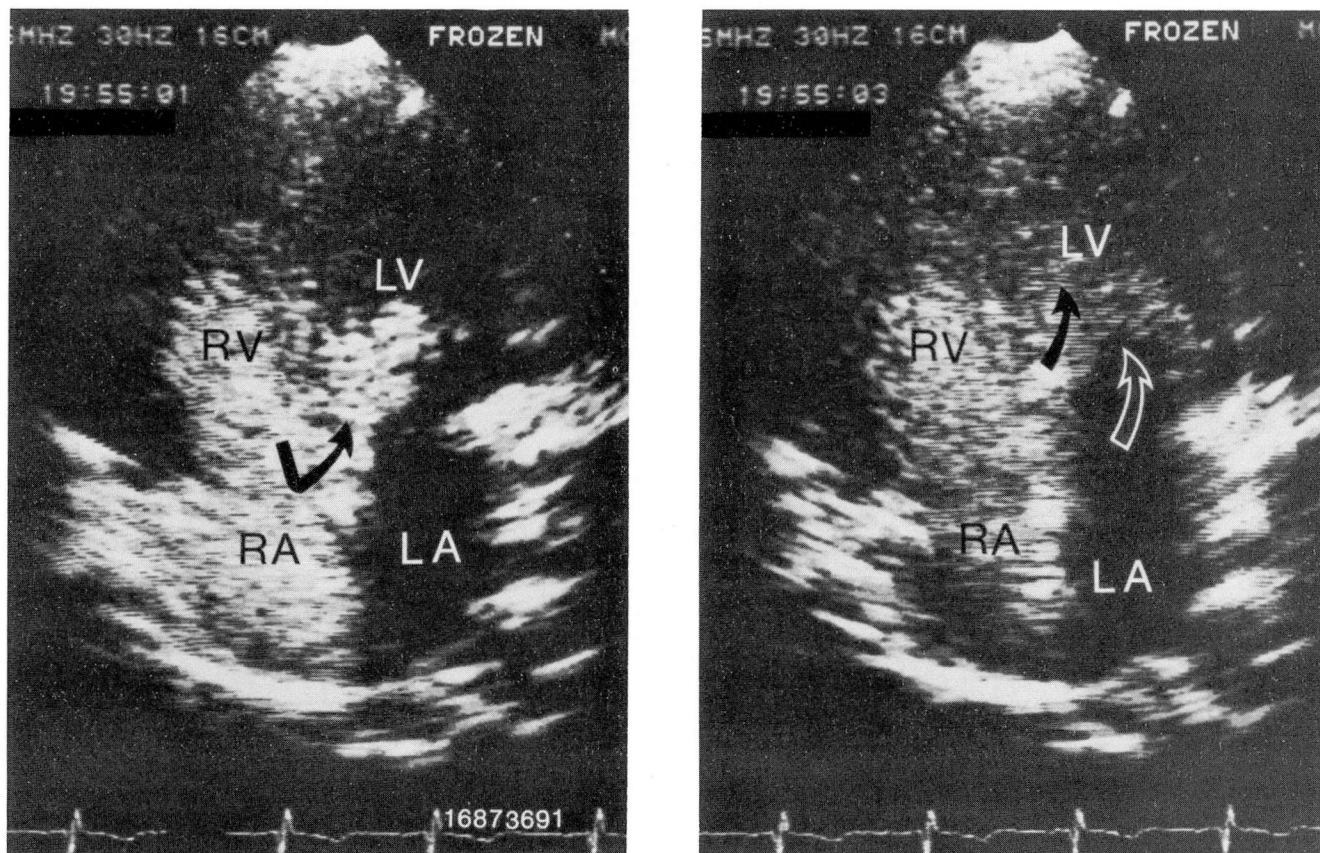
A and B. Apical four-chamber view shows contrast material from the right to the left ventricle through a ventricular septal defect (black arrows). The open arrow shows the mitral valve. LA = left atrium, LV = left ventricle, RA = right atrium, and RV = right ventricle.
